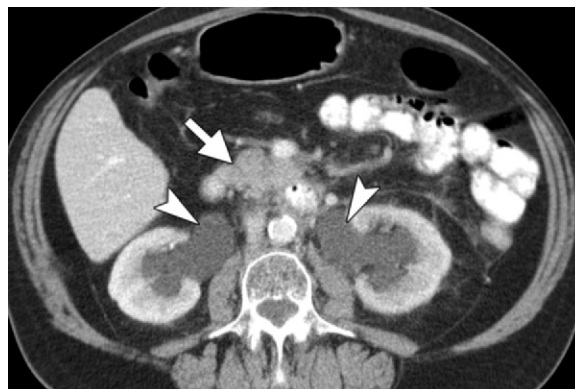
Breast cancer in a 73-year-old woman. Axial CT image obtained 60 seconds after contrast material administration shows a retroperitoneal soft-tissue mass (arrow) but no anterior displacement of the aorta. However, the mass has a lobulated anterior margin. Its malignant nature was confirmed with biopsy. Note the bilateral hydronephrosis (arrowheads) due to ureteral encasement.
